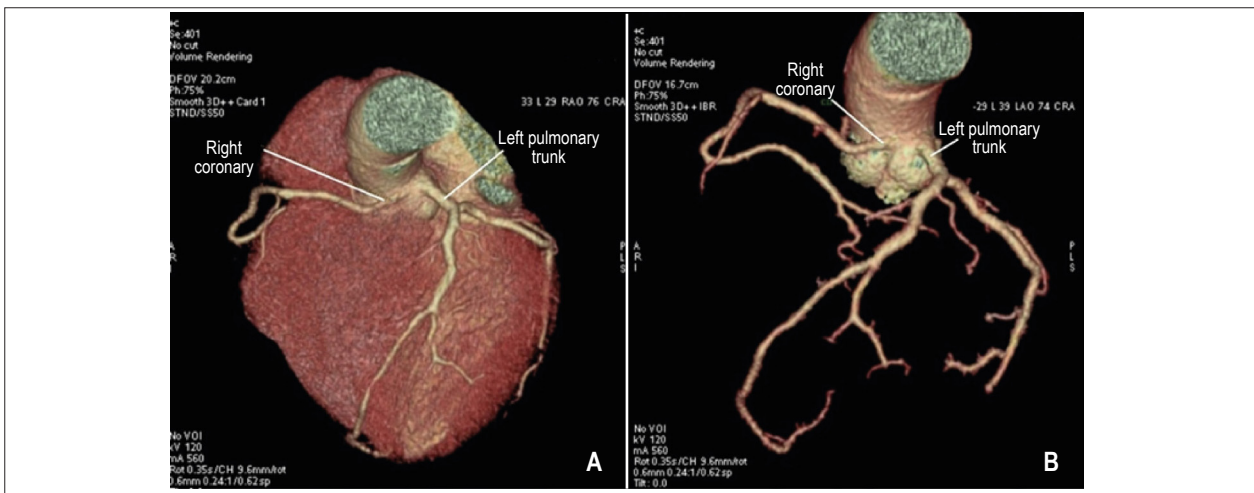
Computed tomography angiography. A e B: Improper RCA origin in the left Valsalva sinus, adjacent to the origin of the left main coronary artery.
